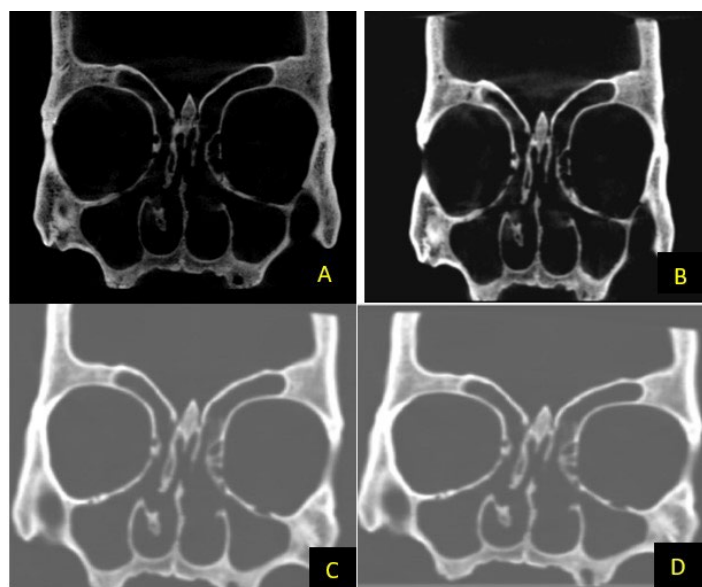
Coronal sections; (A) high-resolution CBCT; (B) low-resolution CBCT, (C) high-resolution CT, (D) low-resolution CT
